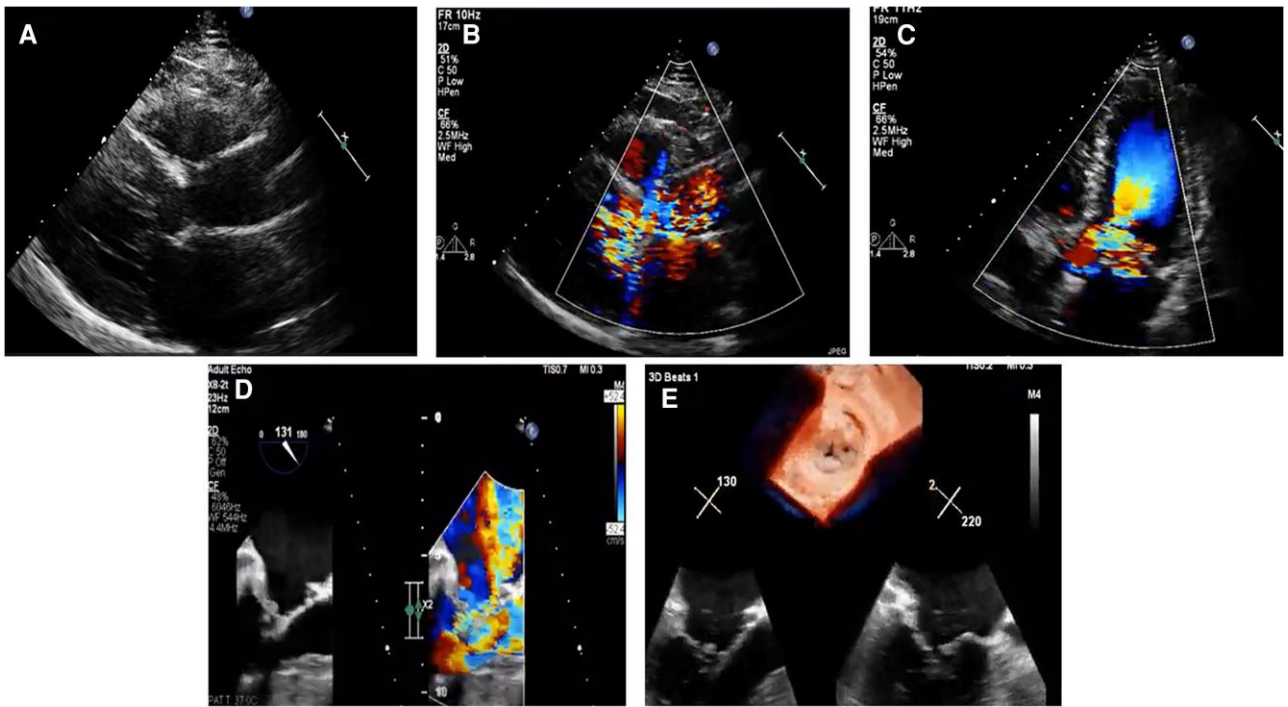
(A–E) Transthoracic echocardiography showing septal hypertrophy, systolic anterior motion of the anterior mitral valve leaflet and significant mitral regurgitation secondary to P2 and A3 prolapse.
